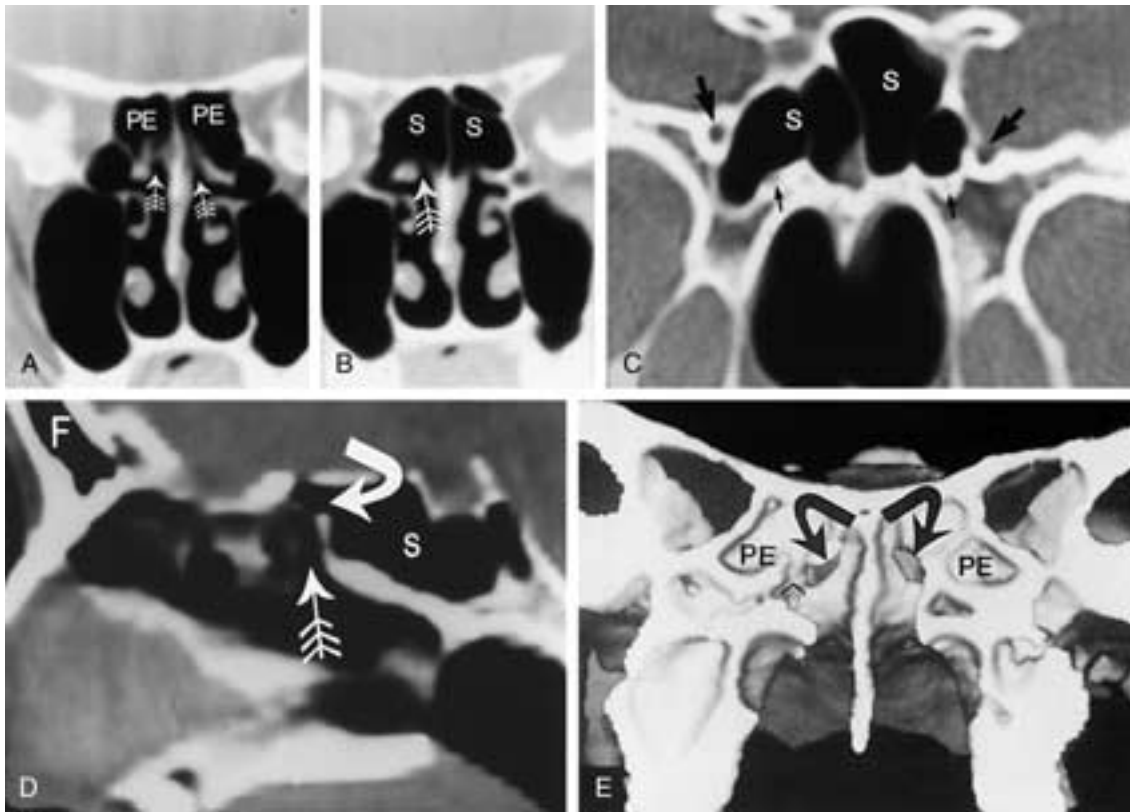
Sphenoid sinus anatomy. A and B, Coronal CT images show the boundary between the posterior ethmoid sinus (PE) and the sphenoid sinus (S). This boundary is best recognized by the position of the sphenothmoidal recess (feathered arrows). It is relatively clear that the coronal image is through the anterior sphenoid sinus when only the inferior edge of the sphenothmoidal recess is identified (B). C, Coronal CT image through the sphenoid sinus (S) shows the number and orientation of septations within the sinus, as well as the relationship to the foramen rotundum (heavy black arrow) and vidian canal (fine black arrow). D, Paramedial sagittal CT image shows the position of the sphenoid sinus ostium (curved arrow) and the sphenothmoidal recess (feathered arrows). Frontal sinus (F), and sphenoid sinus (S). E, Three-dimensional CT image with a coronal cut-plane view through the posterior aspect of the posterior ethmoid sinus (PE) reveals the orientation of the sphenothmoidal recess (open arrow) and position of the sphenoid sinus ostia (curved arrows).
